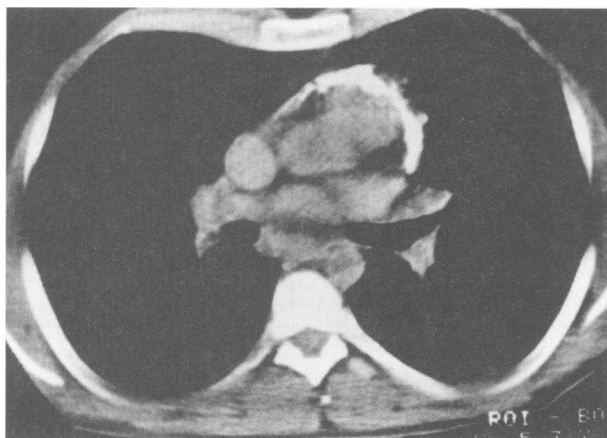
Computed tomography of the chest in another patient with CP demonstrating a thickened pericardium (>4 mm.) (Courtesy of Paul Stark).
